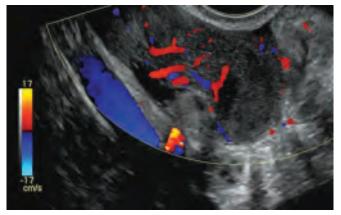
Color Doppler ultrasound of a patient with acute PID. Note complex adnexal mass (usually multilocular cystic structure with echogenic fluid and thick septations) and free fluid in the cul-de-sac. Dilated vessels indicate increased angiogenesis
